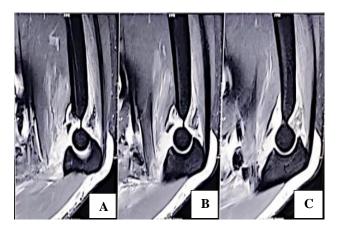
(A-C): Pre-operative MRI (sagittal view) of right elbow joint showing coronoid process avulsion attached to the anterior capsule.
